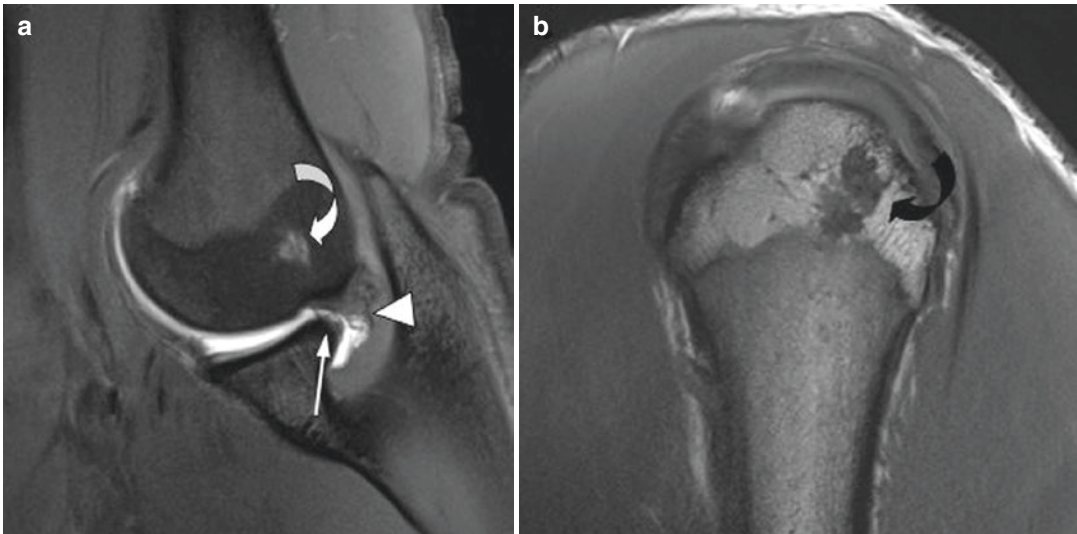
18-Year-old baseball pitcher with shoulder pain. (a) Fat-suppressed T1-weighted abduction external rotation (ABER) view from an MR arthrogram of the shoulder demonstrates tearing of the posterosuperior labrum (arrow), articular surface tearing of the posterior supraspinatus tendon fibers (arrowhead), and cystic changes
